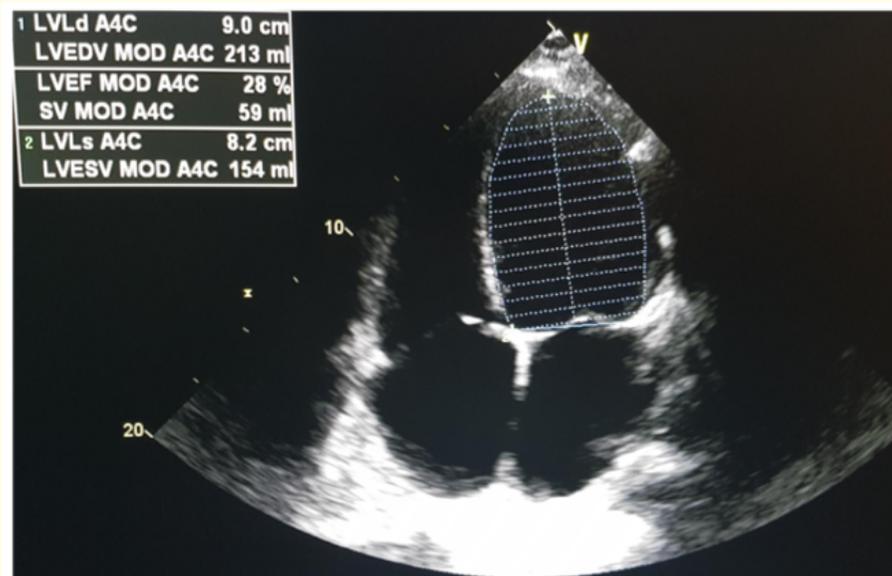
Transthoracic echocardiogram revealed reduced ejection fraction of 25 to 30%, left ventricle was moderately dilated, global hypokinesis of the left ventricle, left atrium and right atrium were mildly dilated.
